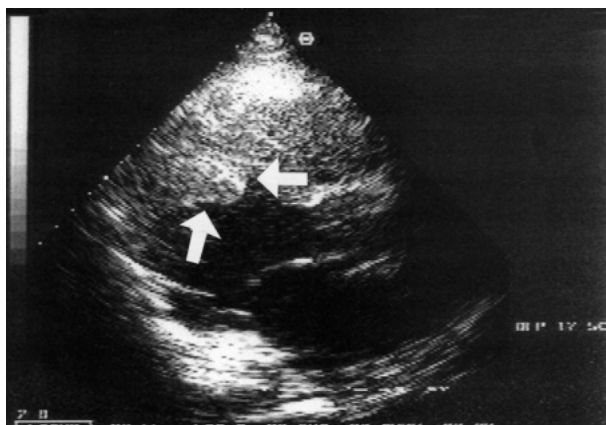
Echocardiogram of the case patient showing a calcified thrombus in the left ventricle (arrows).
